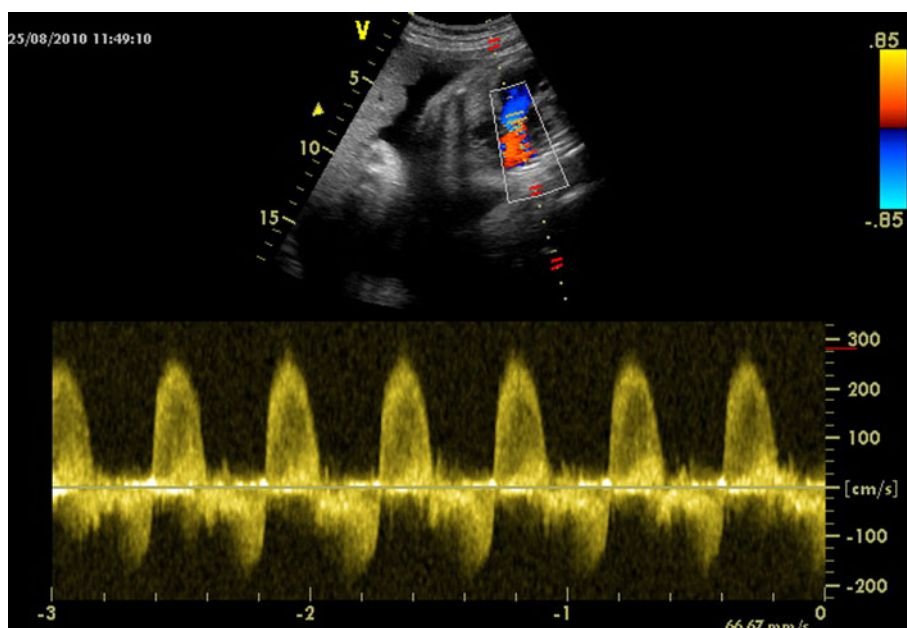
Color-coded fetal echocardiography showing severe pulmonary regurgitation
